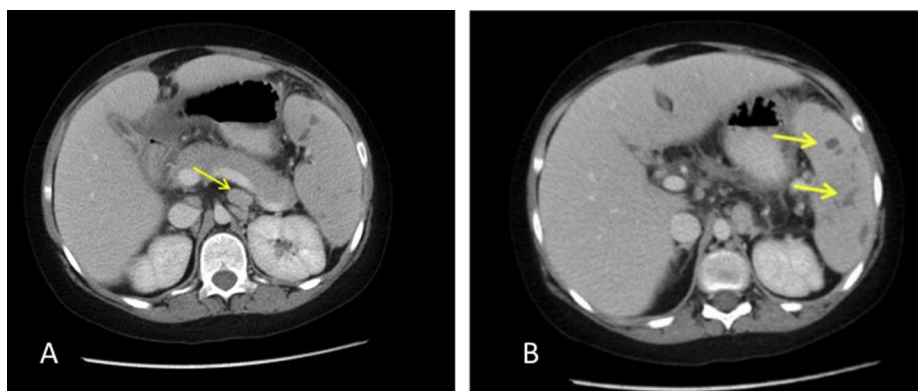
Abdominal CT scan that showed multiple enlarged mesenteric and retroperitoneal lymph nodes (1A) and a bulky spleen (measured to be 12.7 cm) with multiple focal hypodense lesions; the largest was 2.2 cm in its transverse dimension (1B).
